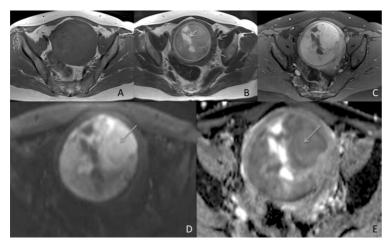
Uterine tumor resembling ovarian sex-cord tumor in a different 50-year-old patient, reproduced from Cho et al. [12] with permission. The pelvic MRI shows an approximately 8.7-cm, round, solid mass in the right anterolateral portion of the uterus. The mass is isointense on T1-weighted image (6A) and hyperintense on T2-weighted image (blue circle on 6B) relative to the rim of myometrium (red arrows on 6B). The mass also contains cystic portions which are slightly hypointense on T1-weighted image and hyperintense on T2-weighted image (orange arrow on 6B). The solid portion demonstrates hyperenhancement on post contrast T1-weighted image (5C). The solid portions of the tumor shows slightly restricted diffusion which appears hyperintense on the diffusion-weighted image and hypointense on the corresponding apparent diffusion coefficient (ADC) map (green arrow 6D and 6E).
